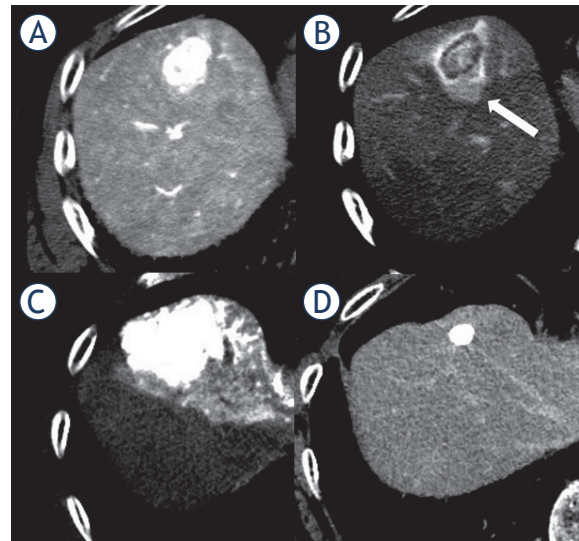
Complete response after transcatheter arterial chemoembolization (TACE) in a 77-year-old patient with a hepatocellular carcinoma. (A) Early-phase computed tomography during hepatic arteriography (CTHA) demonstrated a hypervascular nodule in S4. (B) Late-phase CTHA demonstrated the corona enhancement around the tumor (white arrow). (C) Non-contrast-enhanced computed tomography performed immediately after TACE showed dense accumulation of iodized oil beyond corona enhancement area. (D) Contrast-enhanced computed tomography performed 15 months after TACE showed no enhancement around the tumor.
